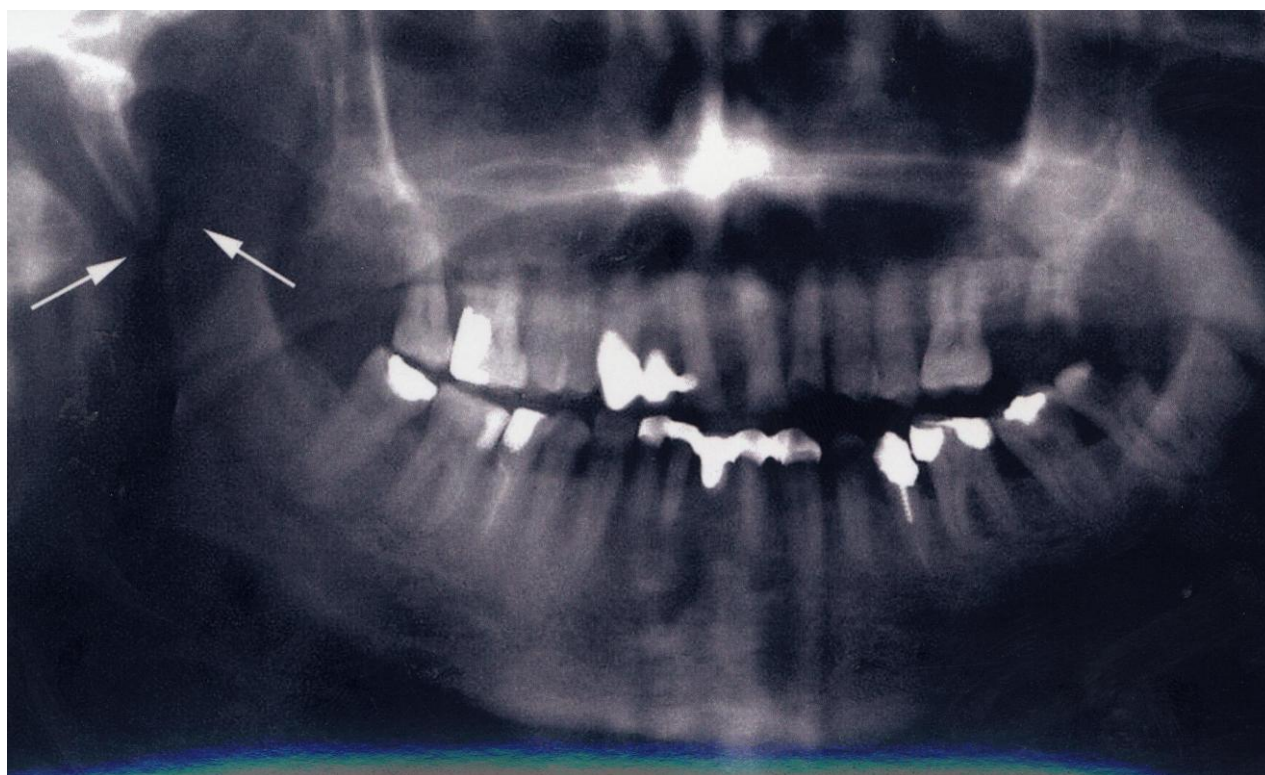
Panoramic radiograph showing fracture of right temporomandibular condyle. (arrows)
